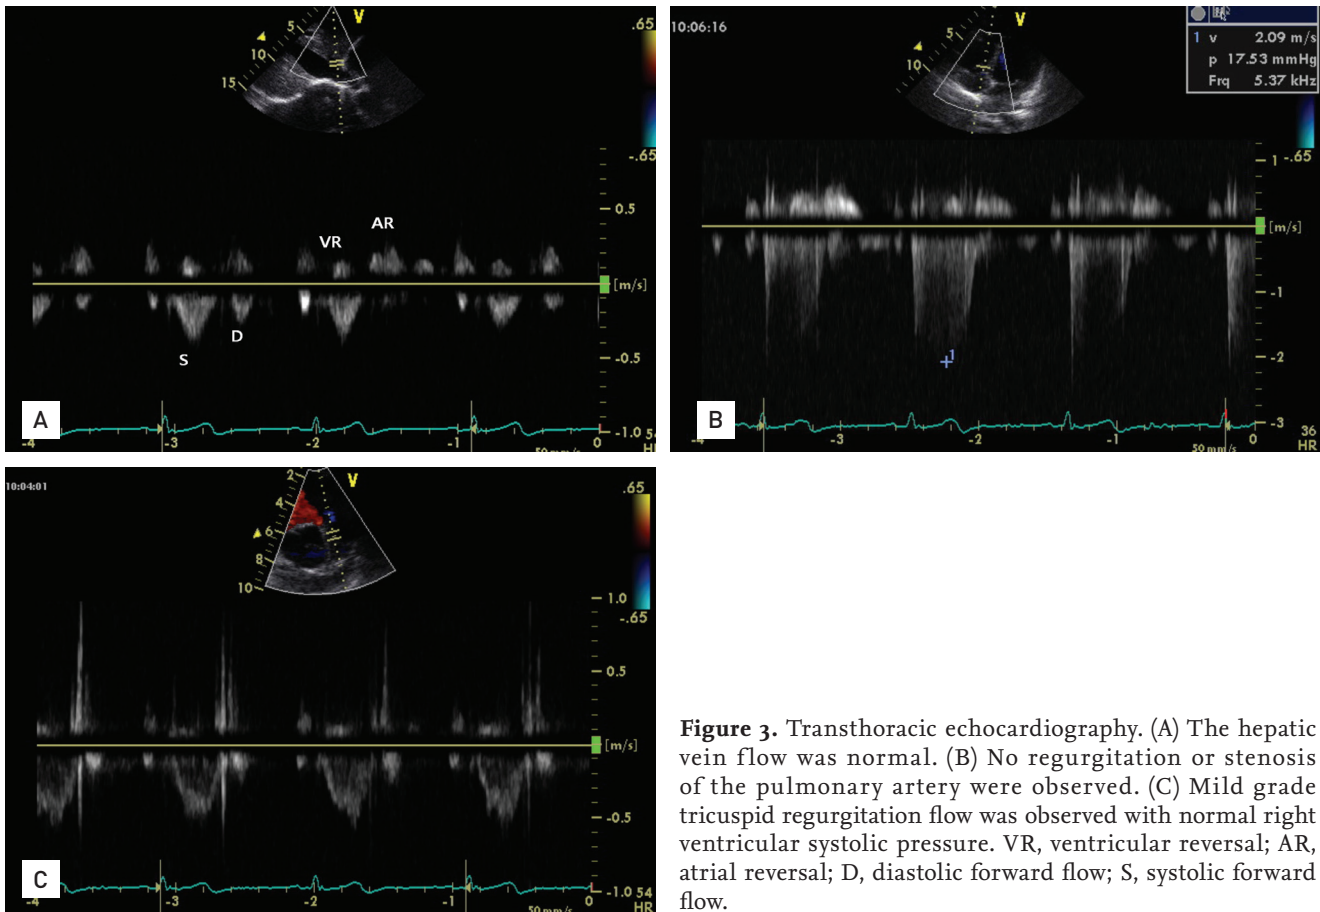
Transthoracic echocardiography. (A) The hepatic vein flow was normal. (B) No regurgitation or stenosis of the pulmonary artery were observed. (C) Mild grade tricuspid regurgitation flow was observed with normal right ventricular systolic pressure. VR, ventricular reversal; AR, atrial reversal; D, diastolic forward flow; S, systolic forward flow.
